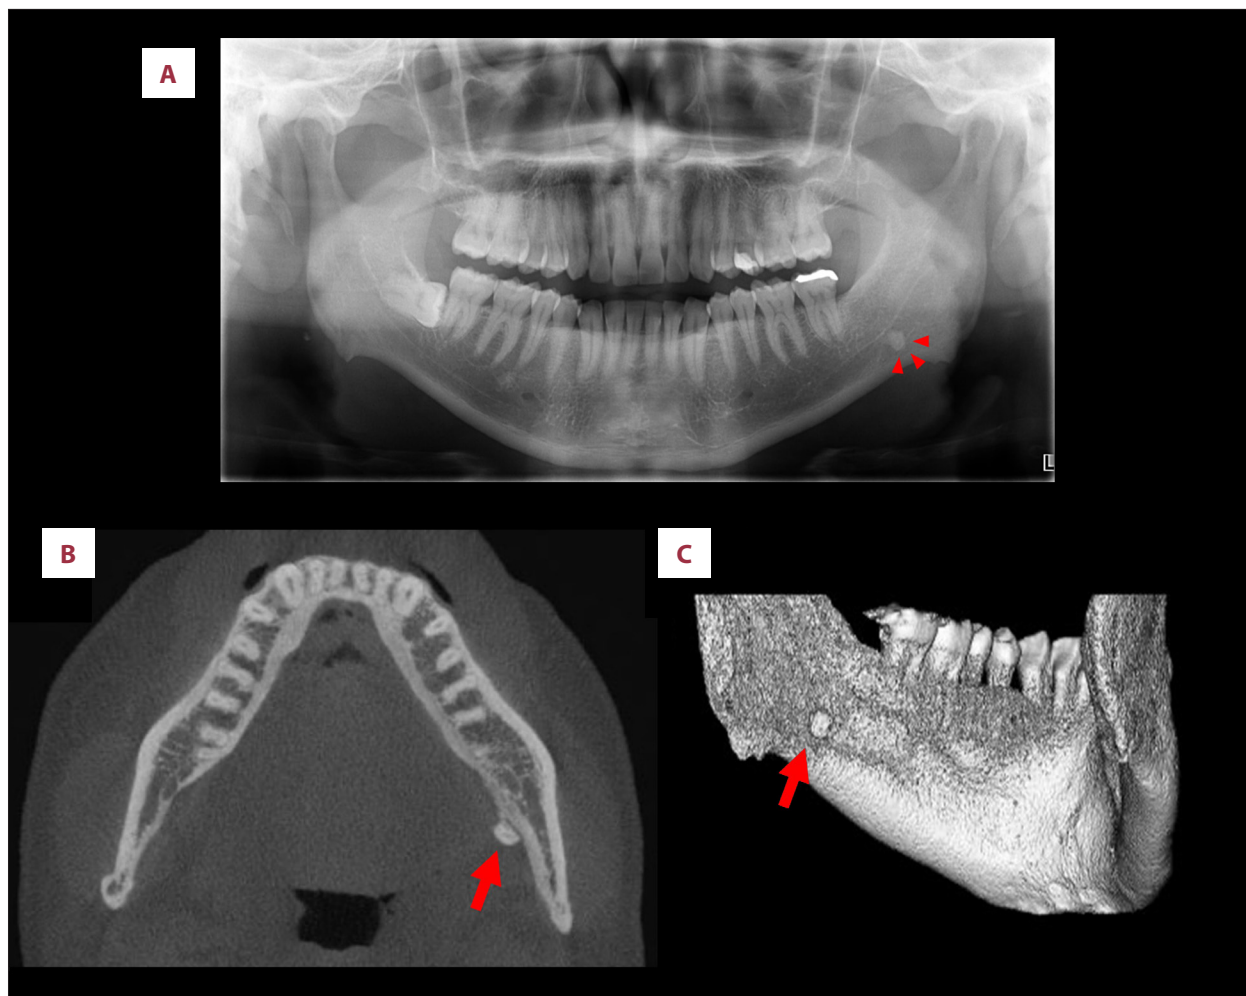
Panoramic radiograph and CBCT images. (A) Panoramic radiograph showing hard tissue on the left side of the mandible. (B) Axial CBCT imaging showing hard tissue on the lingual side of the left mandible. (C) Three-dimensional CBCT image showing hard tissue under the left mylohyoid line. Arrows indicate the displaced tooth fragment.
